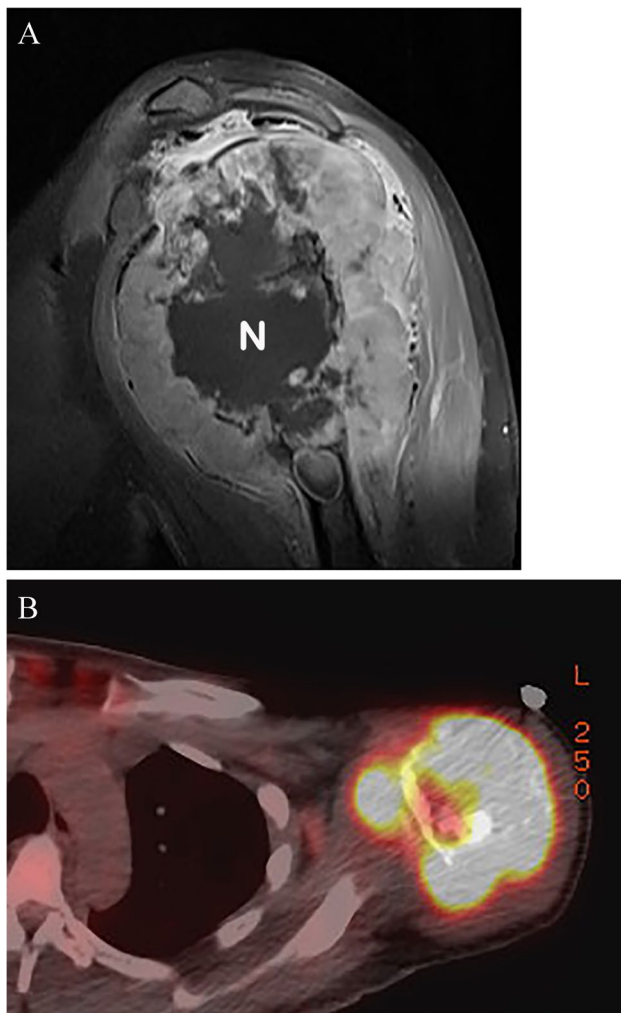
A 28-year-old woman with undifferentiated small round cell sarcoma with *FUS::NFATC2* fusion. (A) Sagittal T1-weighted fat-suppressed image demonstrates an expansile lesion in the proximal humerus. Within the lesion, there is thick peripheral contrast enhancement with central non-enhancement (N), due to necrosis. (B) Axial fused CT-PET image demonstrates intense FDG uptake in the lesion
